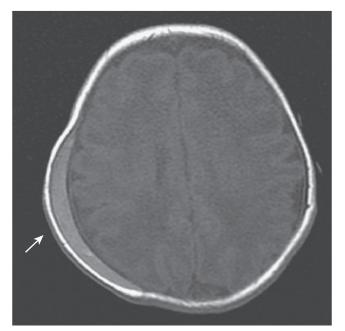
A T1-weighted magnetic resonance imaging scan of a term baby (40 weeks CA) shows a significant increase in the complexity of the gyral pattern compared with the 31 week CA brain shown in the previous figure. At term, the complexity of the cortical gyral pattern approaches that of the adult pattern. The cerebrospinal fluid over the brain surface appears dark in this scan sequence. This scan also shows a subgaleal hematoma over the right parietal area (arrow). The white signal encircling the head represents scalp fat rather than bone; this scalp hemorrhage lies outside the bony cranium. Such extra-axial collections may decrease the recorded voltages over affected areas.
